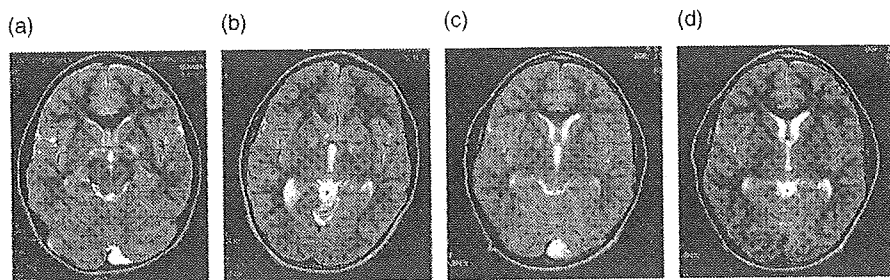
Serial MRI (TR=3000 ms; TE=105 ms for T2-weighted images) of the patient, obtained at 3(a), 6(b), 8(c), and 9(d) years old, respectively. MR images demonstrated a high intensity spot (UBO) in the left globus pallidum at 3 years old, and that in the bilateral globus pallidum at 6 years old (a, b). The UBO gradually disappeared in the left globus pallidum at 8 years old, and in the right globus pallidum, at 9 years old (c, d).
